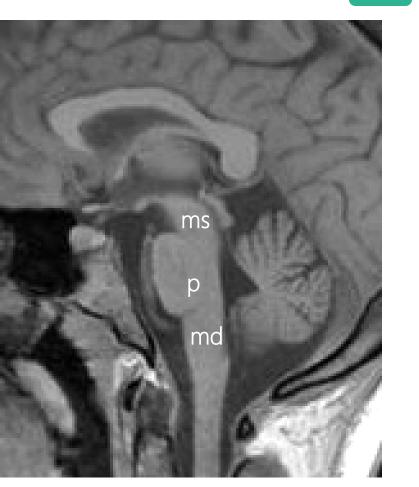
Basic brain stem anatomy on a sagittal T1-weighted MR image.
